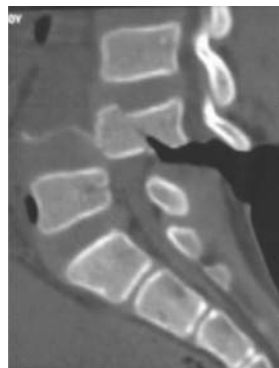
L5- S1 spondyloptosis on non-contrast CT scan.
